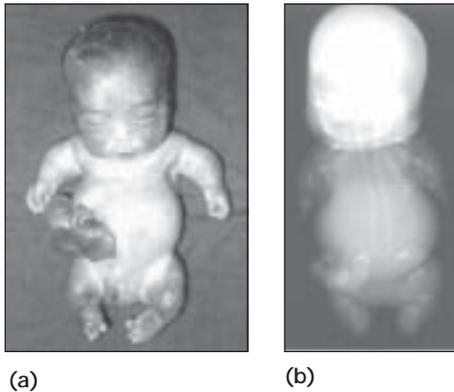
a Foetus with achondroplasia. Note the short limbs and the short and narrow thorax. b Radiograph of the foetus in Figure 20.3a. Note the absence of ossification of vertebral bodies.
